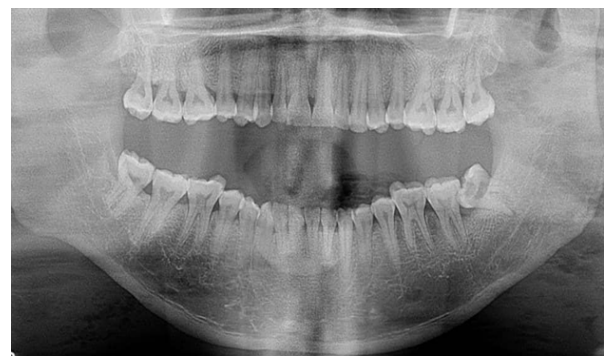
Orthopantomogram (OPG) showing mesioangular impaction of lower left 3rd molar with caries and periapical radiolucency on both roots
